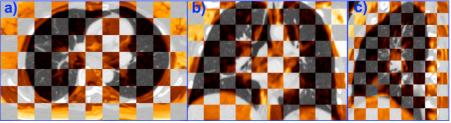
a) Axial, b) coronal and c) sagittal checkerboard view of the 3D T1w-VIBE (orange) and CT image (grey) fusion of a lung adenocarcinoma patient in Pinnacle.
